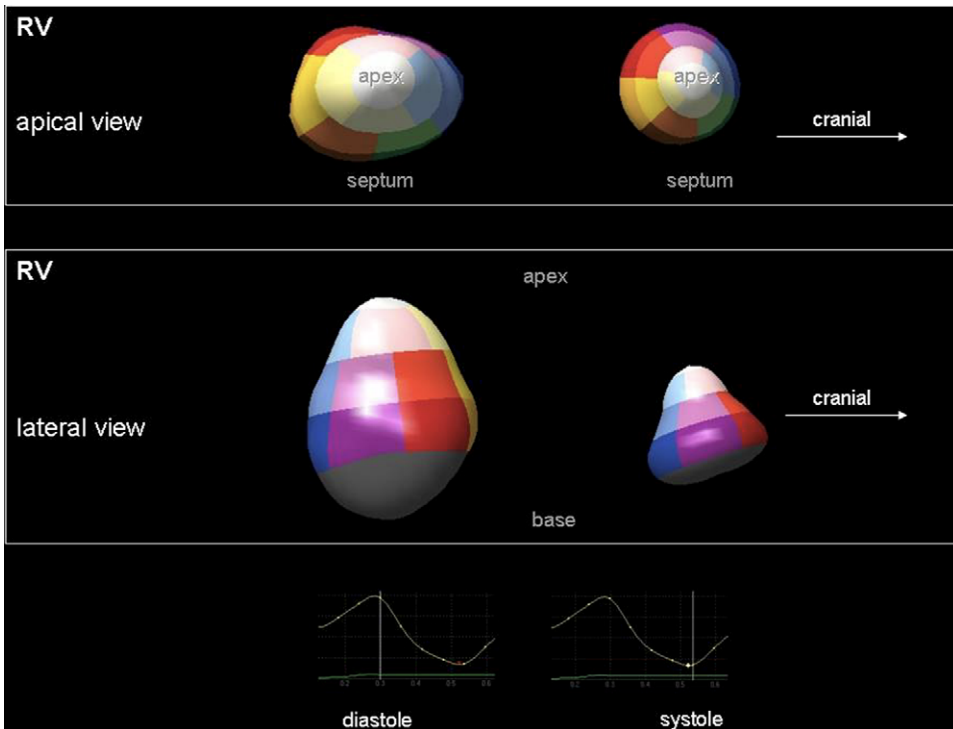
Virtual endocardial casts of the normal human right cardiac ventricle in a 28-week fetus in diastole and systole and endocardial volume curves, generated using semiautomatic volume calculation software from a volume loop acquired using real-time 3D echocardiography (QLab 3DQAdvanced and x3-1/iE33; Philips Medical Systems).
